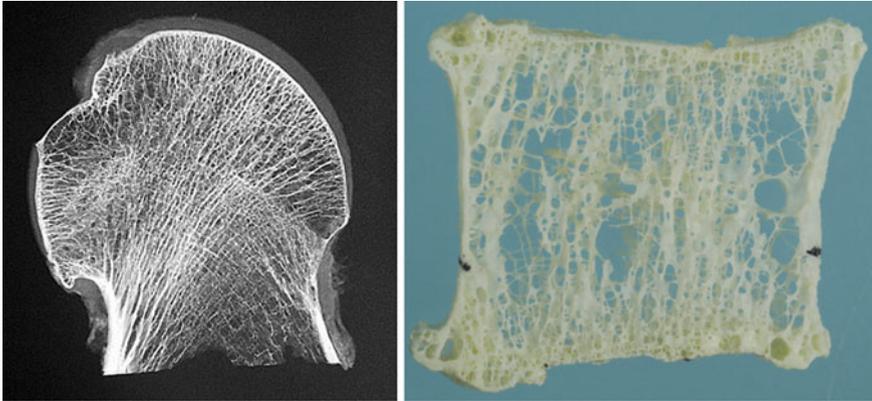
X-ray image of a sagittal slice from the proximal femur, which shows the complex patterns formed by trabeculae
